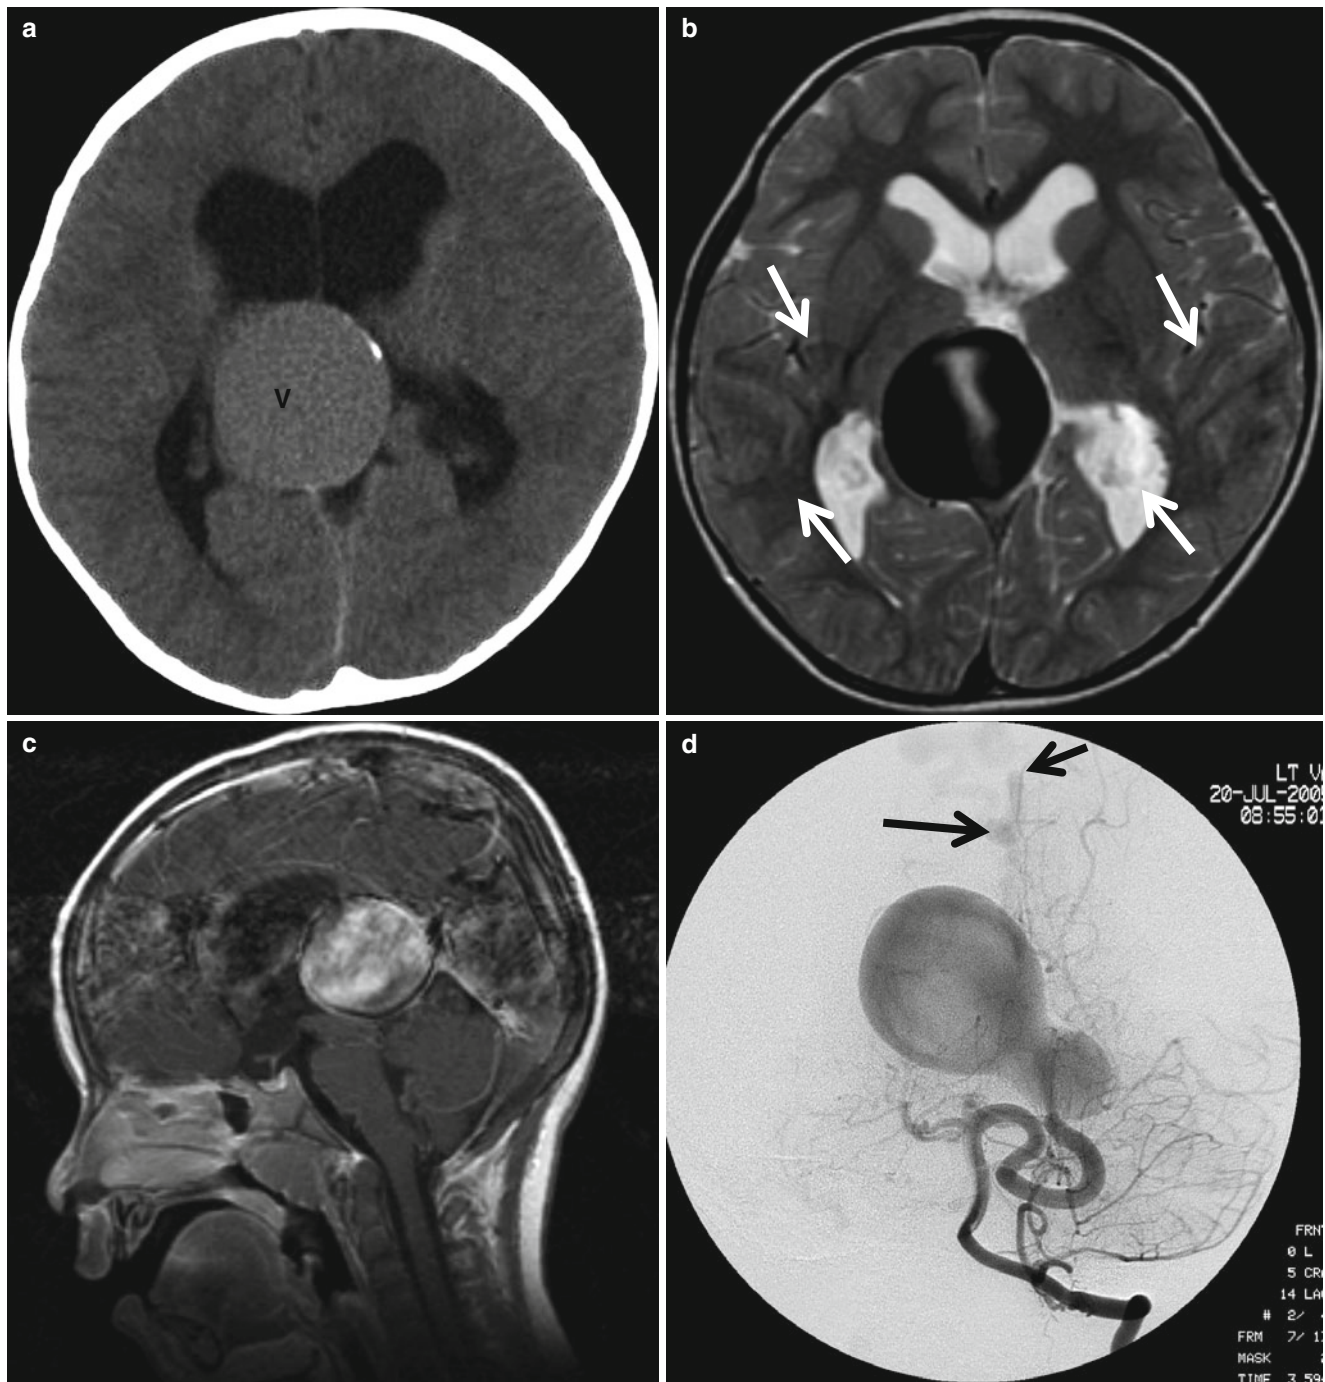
Vein of Galen malformation in a 3-year-old boy. (a) Precontrast CT scan shows large central venous lesion (V) with ventricular enlargement. (b) T2-weighted image demonstrates dark signal intensity of the vein with phase misregistration artifact (*arrows*) due to the vascular flow. (c) Postcontrast sagittal T1-weighted image demonstrates markedly dilated central vein (vein of Galen) and more prominent phase misregistration artifact. Aqueductal compression caused
